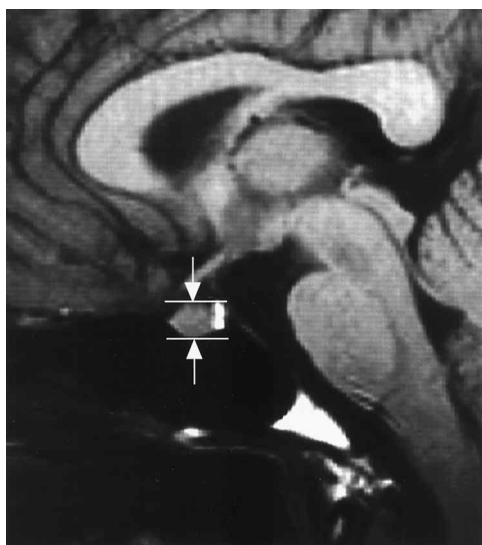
Midsagittal T1-weighted (500/20/2) spin-echo MR image of the pituitary gland (arrows indicate the pituitary height).
